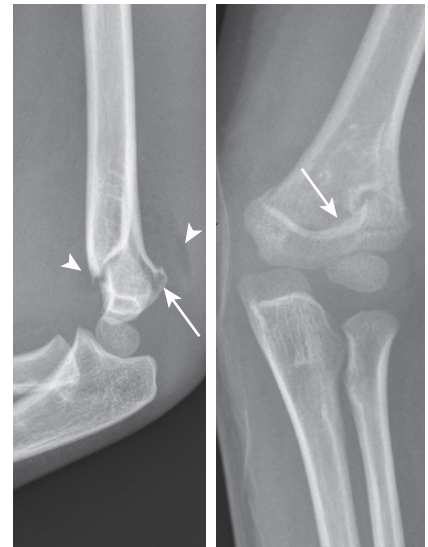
Lateral and antero-posterior radiographs of the elbow in a child demonstrating a posteriorly angulated supracondylar fracture (*long arrows*) with a large elbow joint effusion resulting in fat pad displacement (*arrowheads*).
